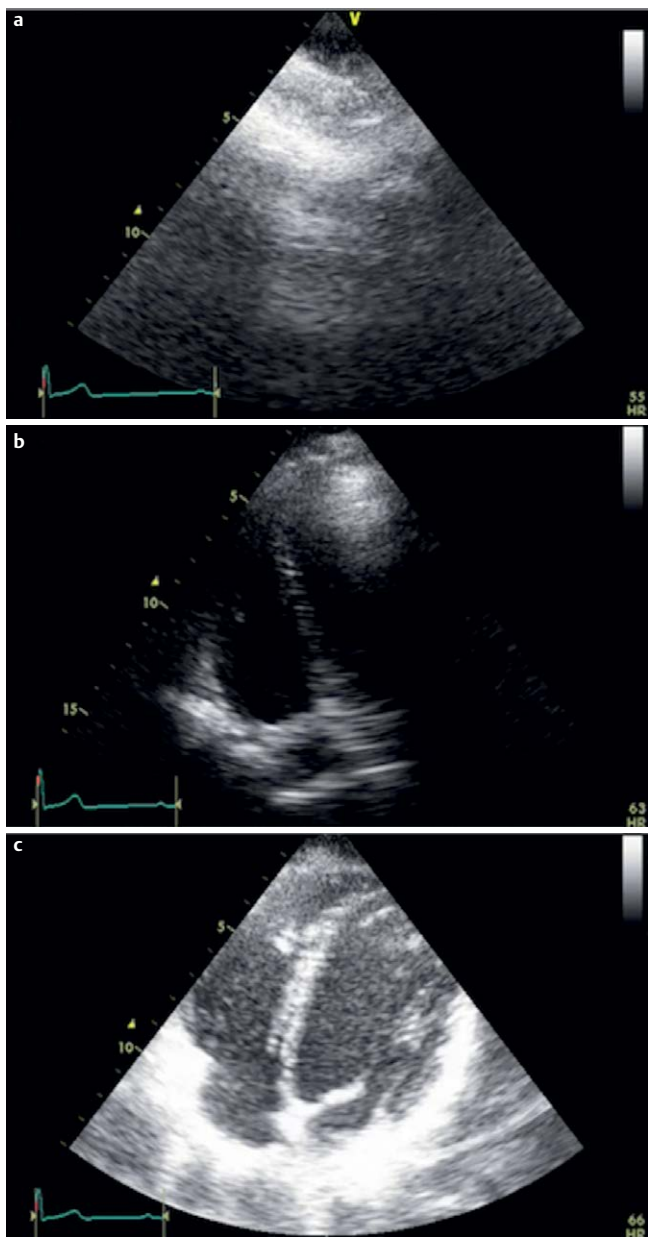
Example of image quality development. Apical 4-chamber view from the 3 tests (student no. 15). a Baseline test; b Intermediate test; c Endpoint test.
